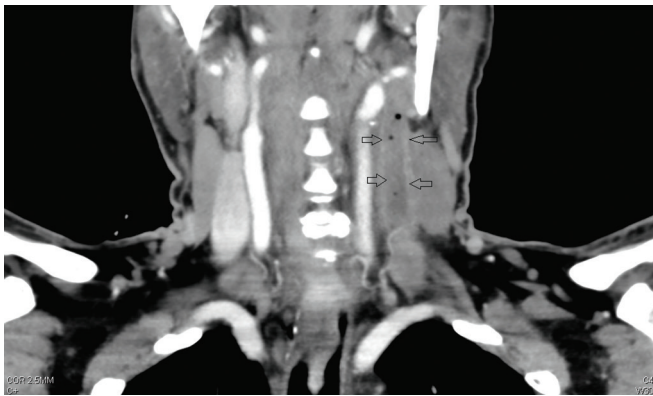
Coronal image of contrast-enhanced CT of neck showing the entire length of the thrombosed IJV extending up to formation of SVC (black arrows)
